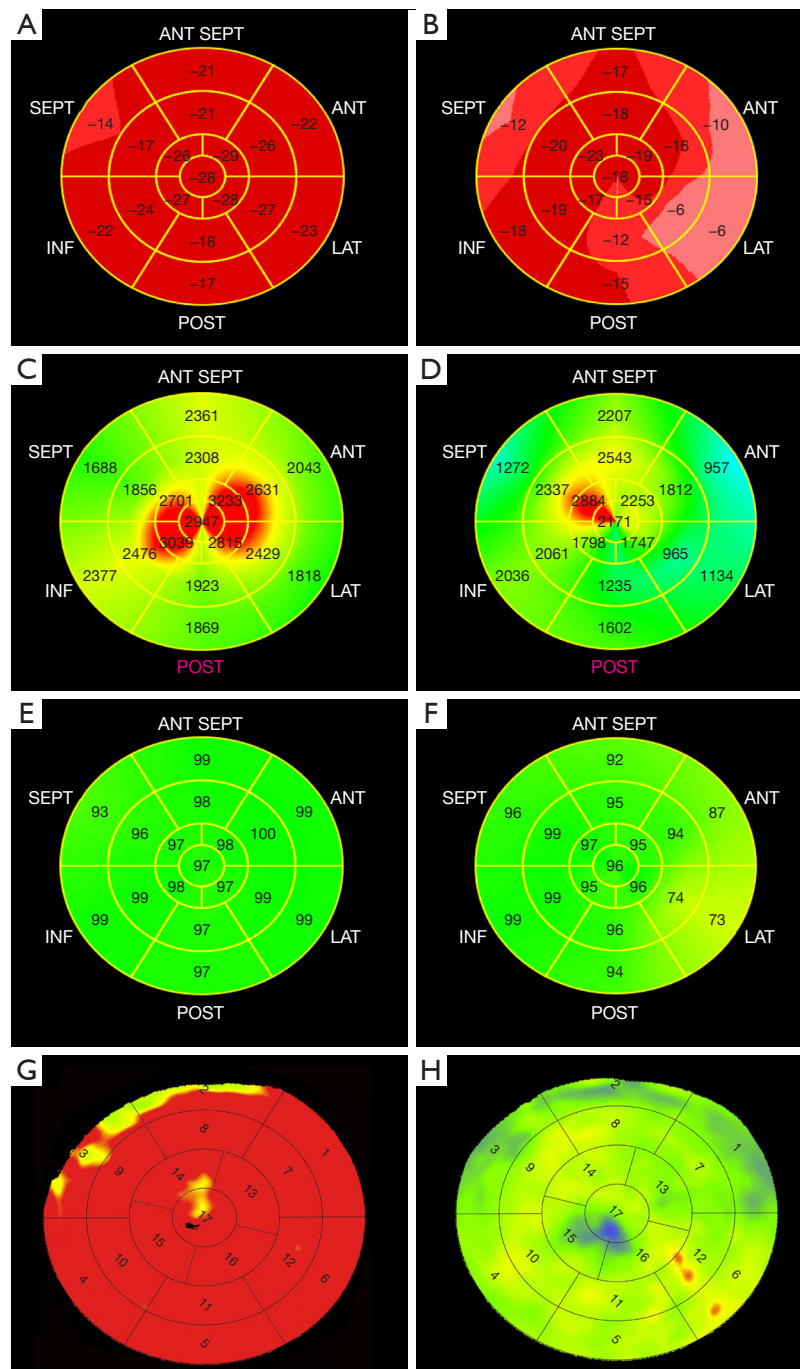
17-segment bull's-eye plots of echocardiographic mechanical indices and stress MBF. (A) Longitudinal strain bull's-eye plot from a subject with normal global stress myocardial perfusion. (B) Longitudinal strain bull's-eye plot from a subject with reduced global stress myocardial perfusion. (C) Work index bull's-eye plot from a subject with normal global stress myocardial perfusion. (D) Work index bull's-eye plot from a subject with reduced global stress myocardial perfusion. (E) Work efficiency bull's-eye plot from a subject with normal global stress myocardial perfusion. (F) Work efficiency bull's-eye plot from a subject with reduced global stress myocardial perfusion. (G) Stress MBF bull's-eye plot from a subject with normal global stress myocardial perfusion. (H) Stress MBF bull's-eye plot from a subject with reduced global stress myocardial perfusion. MBF, myocardial blood flow; ANT-SEPT, anterior interventricular septum; SEPT, interventricular septum; INF, inferior wall; POST, posterior wall; LAT, lateral wall; ANT, anterior wall.
